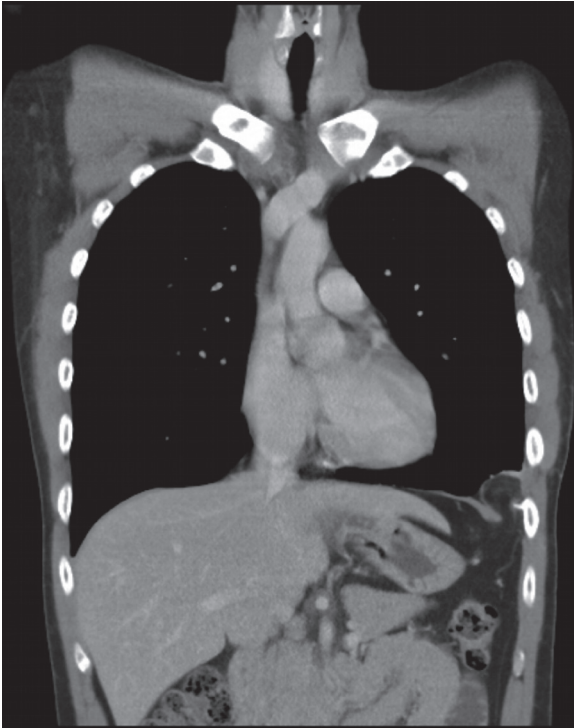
Chest computed tomography showed a left lateral diaphragmatic hernia with herniation of the omental fat.
